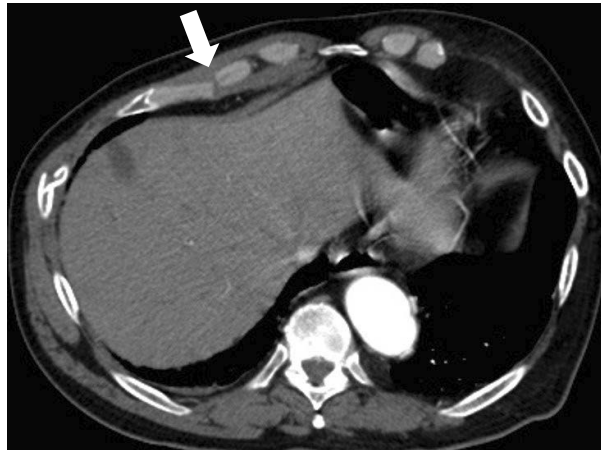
An axial CT-image reveals a traumatic costal cartilage fracture on the right (arrow). The anterior chest wall is slightly depressed on the right due to the multiple rib and cartilage fractures.
